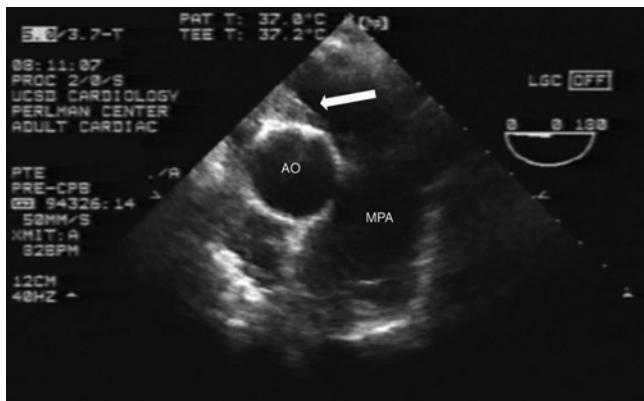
Mid esophageal aortic short-axis transesophageal echocardiograph showing dilatation of the main pulmonary artery and thromboembolic material at the origin of the right pulmonary artery (arrow). MPA main pulmonary artery; AO aorta.
